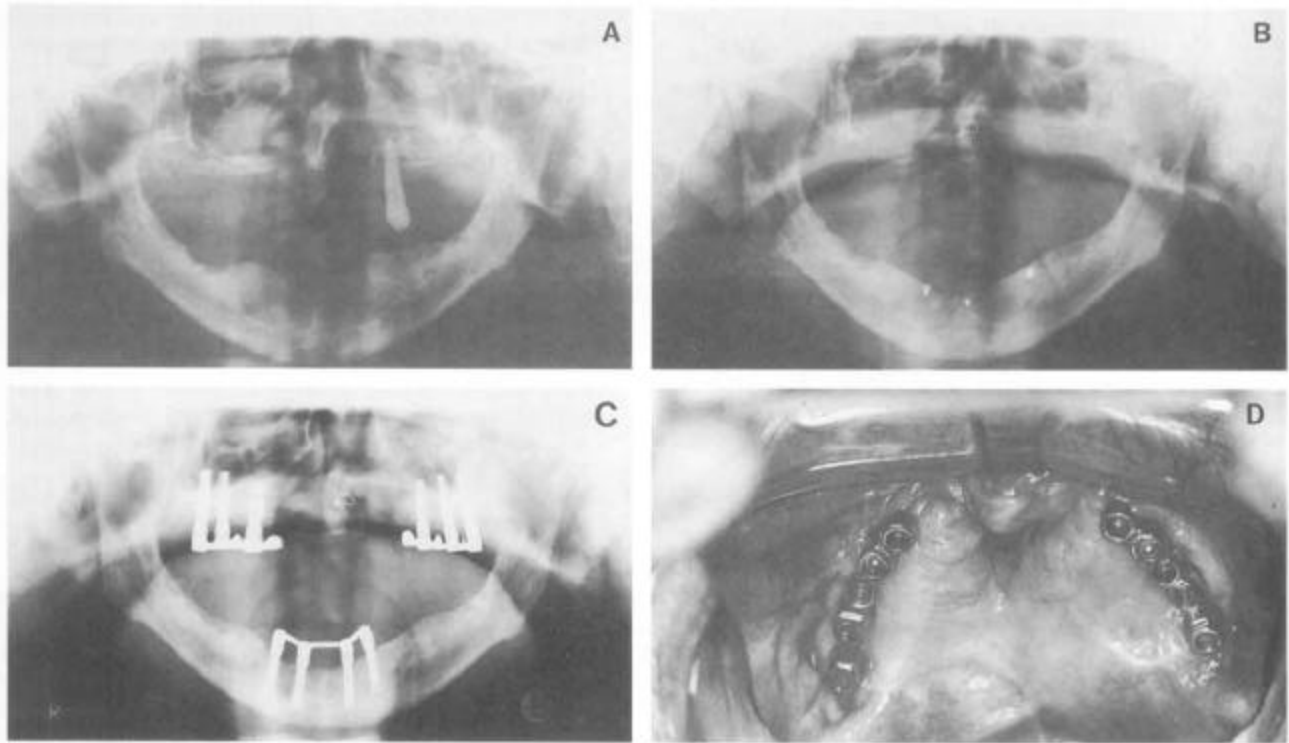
Example of an edentulous 44-year-old male who underwent bilateral augmentation of the maxillary sinus floor and augmentation of the inferior alveolar ridge followed by placement of endosseous implants and rehabilitation with implant-supported overdentures. A: Panoramic radiograph showing the preoperative situation with atrophy of the maxilla. B: Radiograph showing the situation 3 months after bilateral augmentation of the maxillary sinus floor and of the interforaminal inferior alveolar ridge. The bone grafts were harvested from the posterior iliac crest. C: Three months after bone grafting, 10 endosseous implants (Brånemark implants, Nobelbiocare, Göteborg, Sweden) were inserted in the grafted areas. After 6 months, abutments and suprastructures were connected. This is shown on the radiograph. D: Intraoral view of the suprastructures in the maxilla prior to rehabilitation with implant-supported overdentures.
